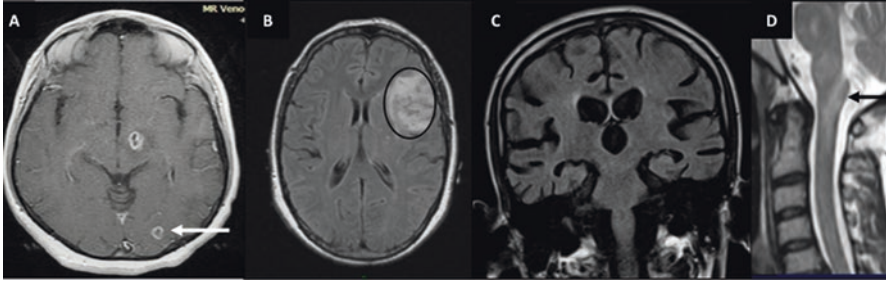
Brain MRI of atypical parenchymal patterns during the parenchymal neuro-Behçet syndrome episodes are shown. (a) Axial T1 Gd (+) image shows a typical midbrain-diencephalic pattern of involvement for NBS but an additional atypical occipital lesion for NBS. (b) Axial FLAIR image shows a hemispheric tumefactive lesion. (c) Coronal FLAIR image reveals significant global cerebral atrophy. (d) MRI reveals area postrema lesion in a patient having BS for 10 years. AQP4 antibody was negative
